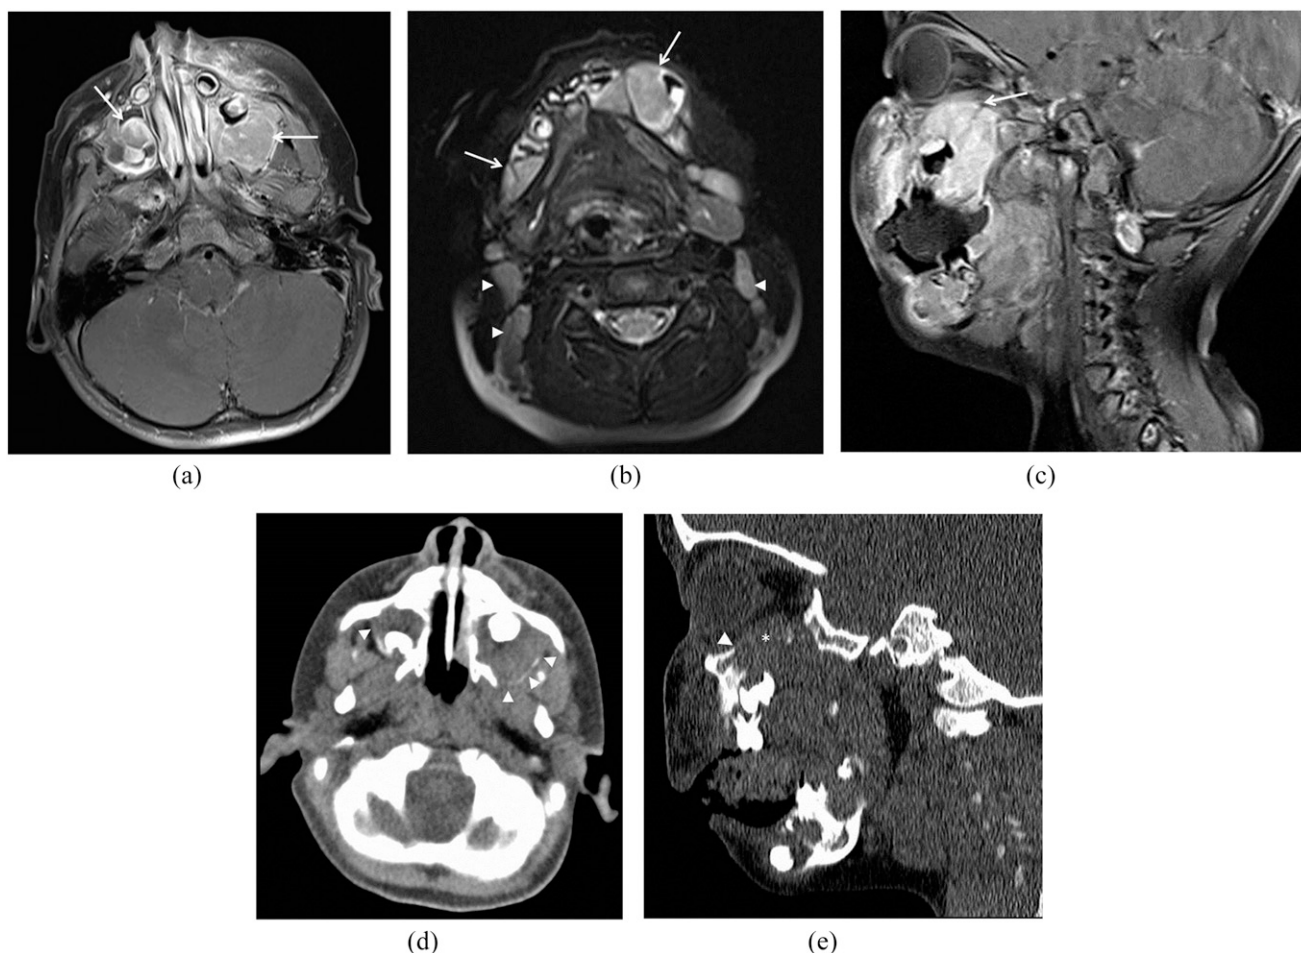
(a–c) MRI and (d, e) CT scan of the face. (a) Axial post-contrast T_1 fat-saturation MRI showing that the bilateral maxillary lesions in axial T_1 (arrows) are larger on the left. (b) Axial T_2 fat-saturation MRI showing multiple mandibular lesions (arrows) and enlarged lymph nodes (arrowheads) in the neck. (c) Sagittal post-contrast T_1 fat-saturation image showing homogeneous enhancement of the maxillary and mandibular mass with extension through the floor of the orbit causing mild mass effect on the inferior rectus muscle (arrow). (d) Axial CT showing a mass around the tooth and expansion of the maxillary sinuses with thinning and erosion of the posterolateral wall of the bilateral maxillary sinus (arrowheads). (e) Sagittal CT showing the edge of the destroyed floor of the orbit (arrowhead) due to mass in the maxillary sinus (asterisk).
